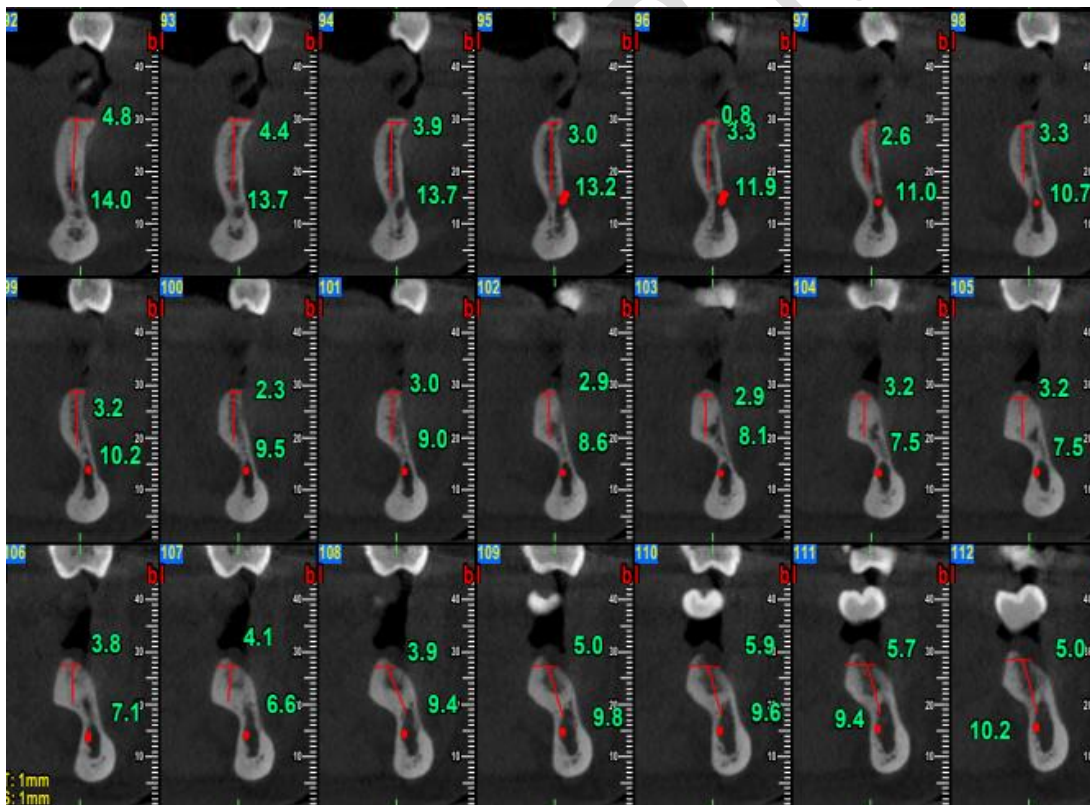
CBCT REPRESENTATION
